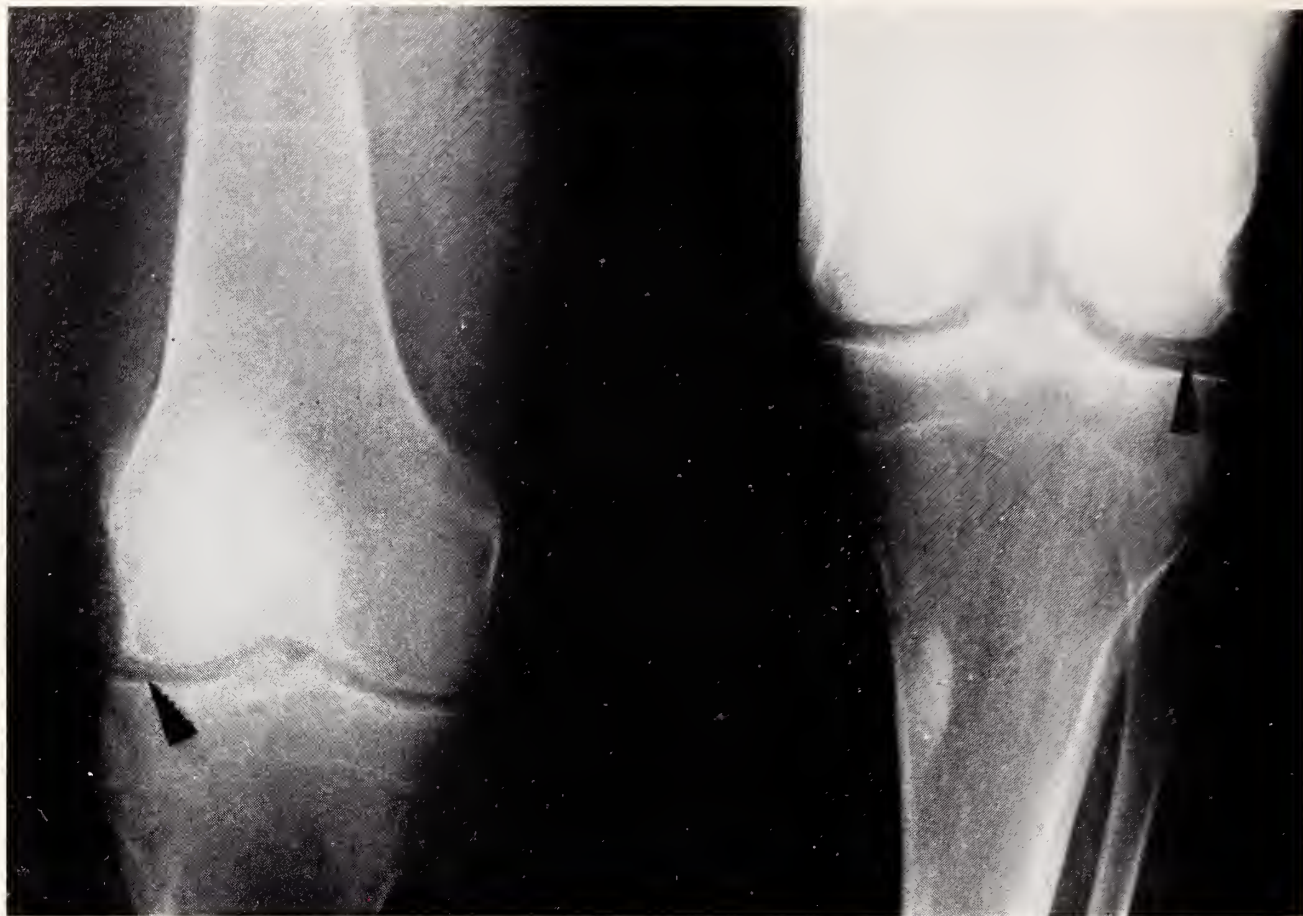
Chondrocalcinosis affecting the knee. Calcification within the articular cartilage is observed. This represents calcium pyrophosphate, and is a roentgen feature of the pseudogout syndrome.
